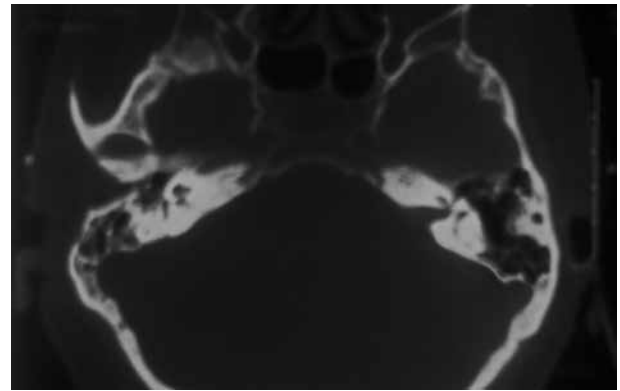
CT scan: Inflammatory changes involving osseous portion of external auditory canal and mastoid process
